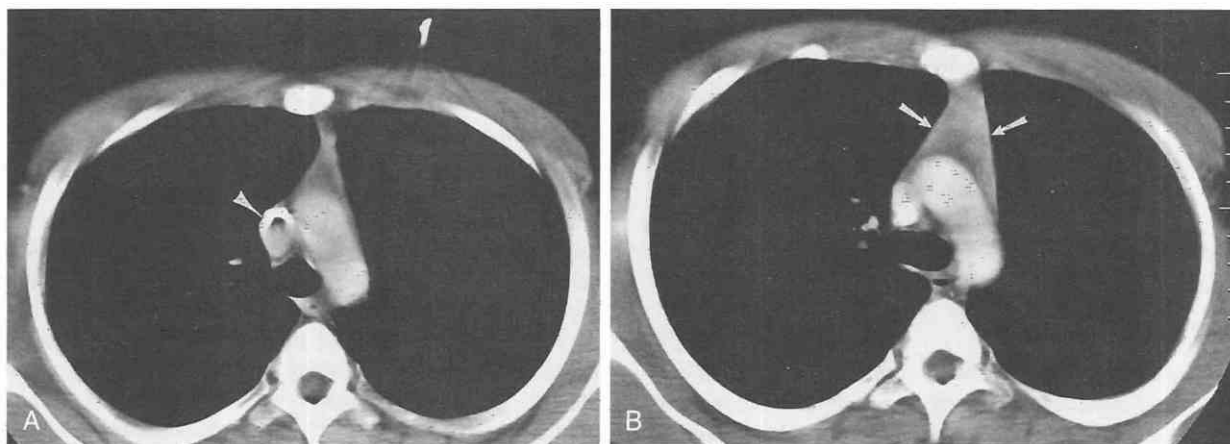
Thymic rebound in a 12-year-old boy treated with chemotherapy. A, CT scan at level of aortic arch obtained while the patient was on chemotherapy demonstrates a lack of soft tissue in the prevascular space. The central line is in place (arrowhead). B, CT scan at the same level obtained 3 months later, when the patient is no longer receiving chemotherapy, demonstrates an interval increase in the soft tissue (arrows) in the prevascular space. The rebounded thymus has a triangular configuration, and the central line is no longer present.
